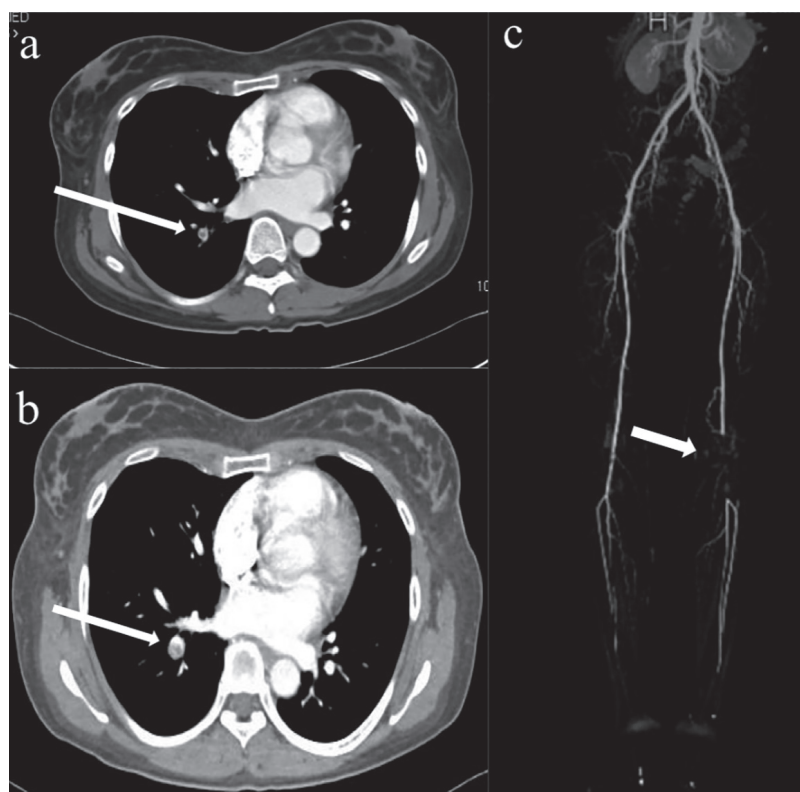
Chest computed tomography (CT) and CT angiography of lower extremity.
